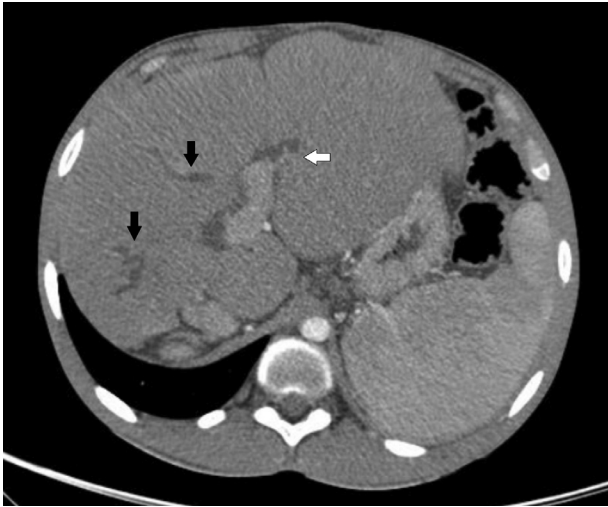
Abdominal computed tomography showing dilation of the intrahepatic biliary ducts (black arrows) and portal vein thrombosis (white arrow).
